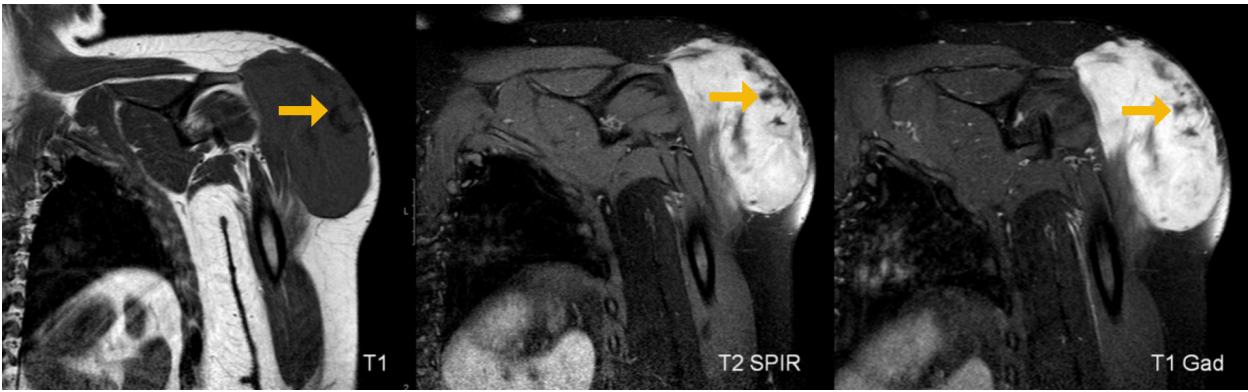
Deep fibromatosis in the left deltoid muscle in a 54-year-old male. MR images showing a well defined mass with heterogenous intermediate signal intensity on T1-weighted images (isointense to the muscle), high signal intensity on T2- weighted images and avidly enhancing. Note the low signal intensity internal areas (arrows) with band like morphology demonstrating lack of enhancement (characteristic of fibromatosis).
